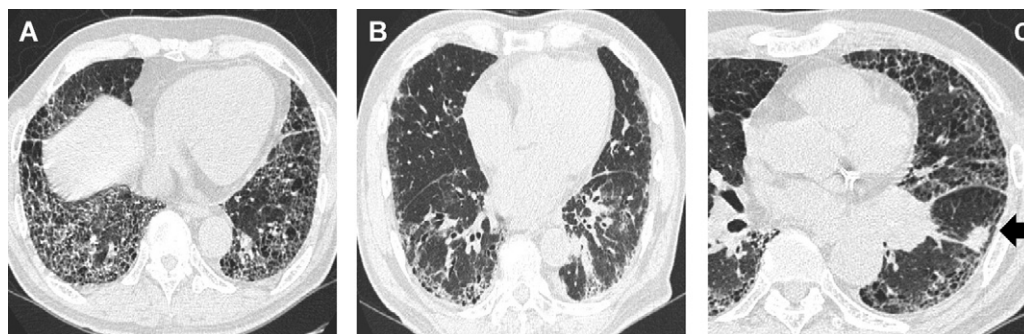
Chest high-resolution computed tomography (HRCT) image of the chest. (A) HRCT scan showing subpleural distribution, honeycomb cysts, and bronchiectasis (UIP pattern). (B) HRCT scan showing patchy ground glass opacity with reticulation, traction bronchiectasis, and bronchovascular bundle thickening (non-UIP pattern). (C) HRCT scan showing a tumor (arrow) in the ILD area (UIP pattern).
